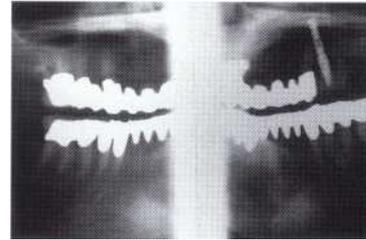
Panorex radiograph showing a solitary integrated implant and inadequate bone height for additional implants.
